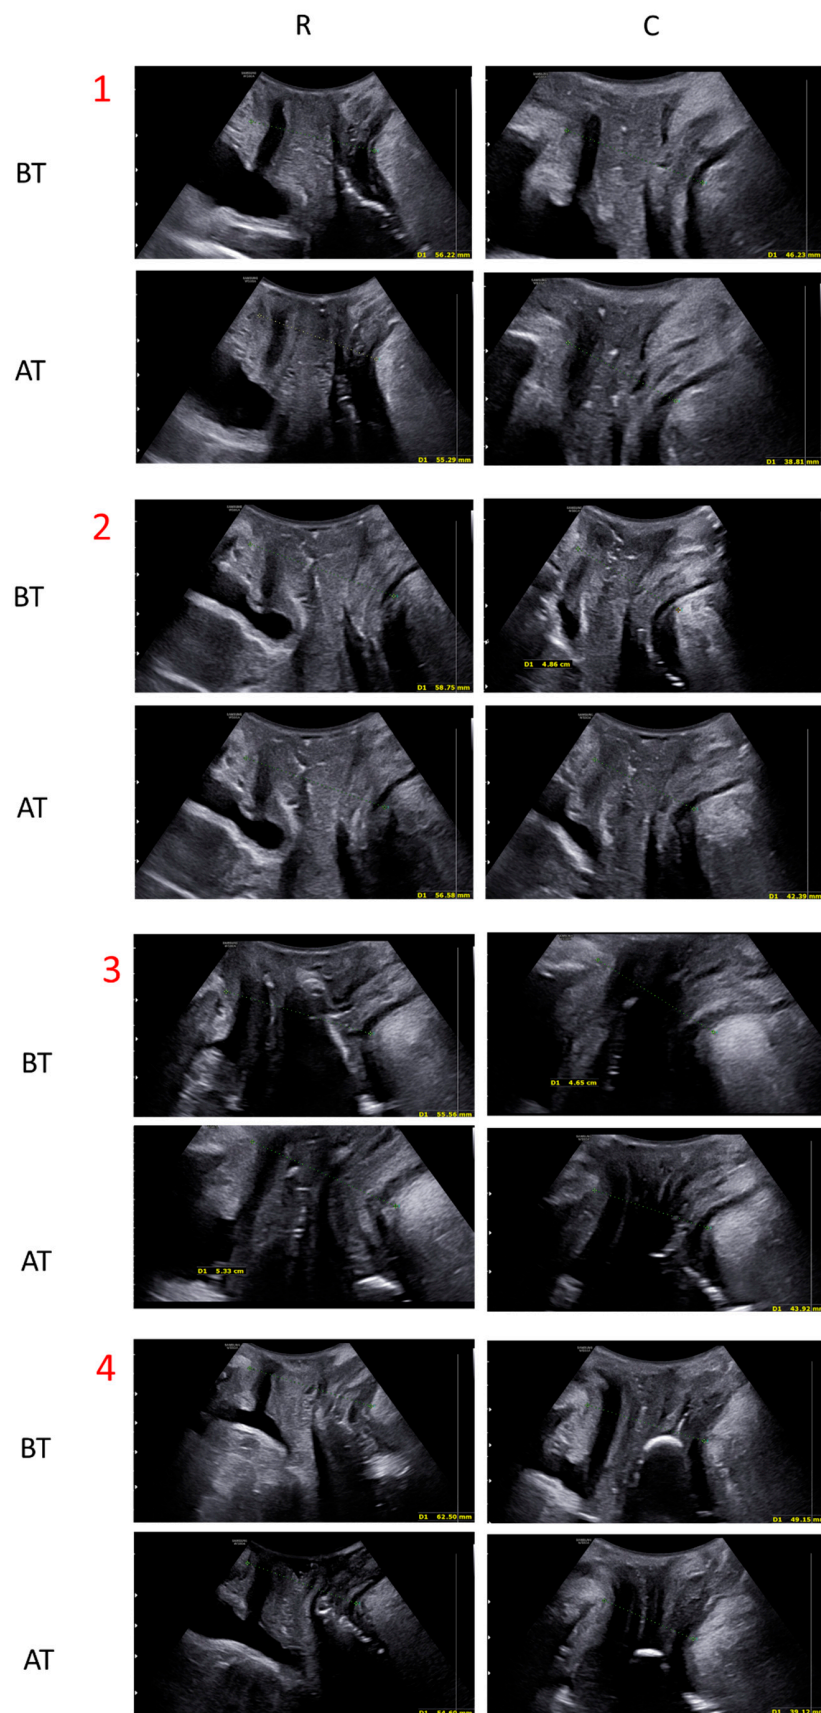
Ultrasound evaluation of four patients before (BT) and after (AT) the treatment with electromagnetic stimulation. For every subject, four pictures were taken. A comparison of a rest (R) condition and under stress/contraction (C) was made.
